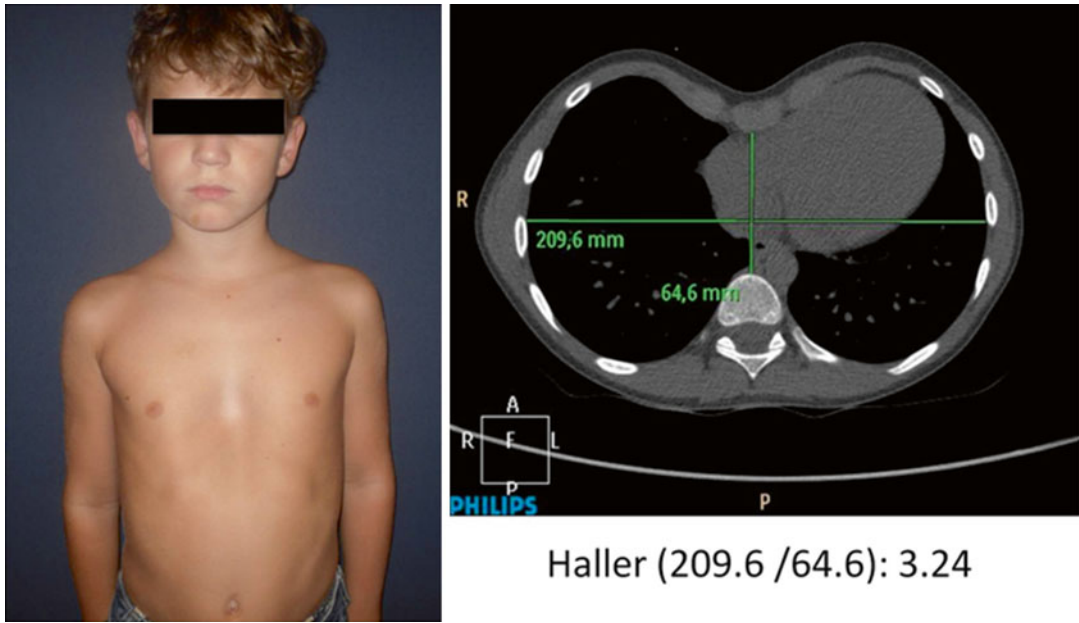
(Left) Patient consulting for PE. (Right) Chest CT Scan revealing a Haller Index=3.24. According to the cut-off point of HI, the patient does not have PE
